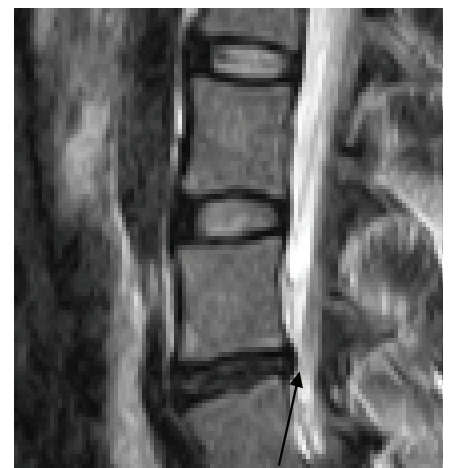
MRI of lumbosacral spine, taken on April 16th, 2007.
